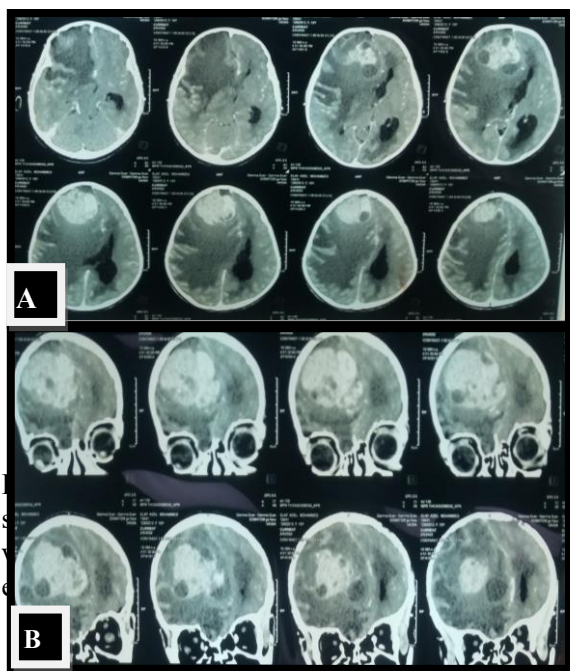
Contrast-enhanced Brain CT scan shows an intra-axial heterogeneous mass within the right frontal lobe with surrounding extensive vasogenic edema and midline shift. A: Axial cuts, B: Coronal cuts.
